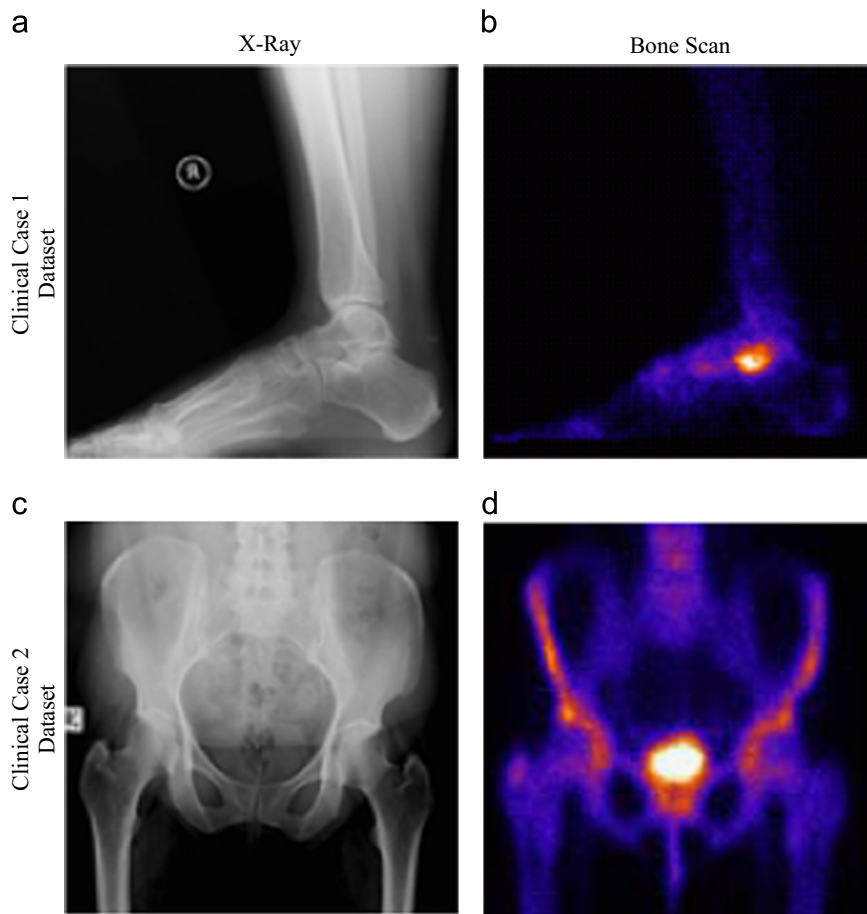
Clinical Case 1: (a) X-ray image and (b) bone scan image; Clinical Case 2: (c) X-ray image and (b) bone scan image.
